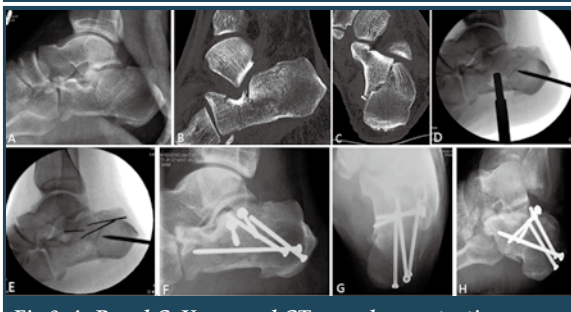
A, B and C: X-ray and CT scan demonstrating displaced intra-articular calcaneal fracture. D: Intra-op X-ray showing insertion of a shanz screw for manipulation of the fracture. The depressed fragment was tamped to restore a normal articular surface. E: Insertion of multiple k-wires to stabilize the fracture sites. F,G,H: Post-op X-rays revealing satisfactory alignment and congruous subtalar joint after fixation by both cannulated and non-cannulated screws.
